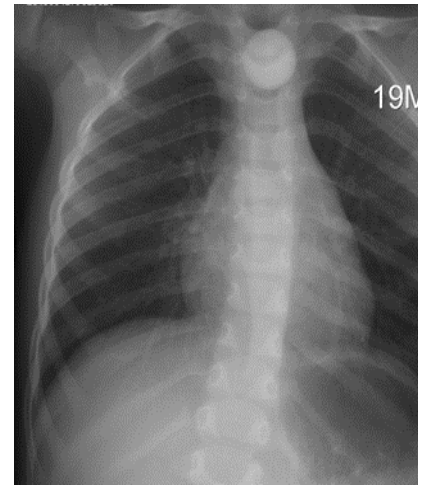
X-ray positive foreign body of the esophagus
